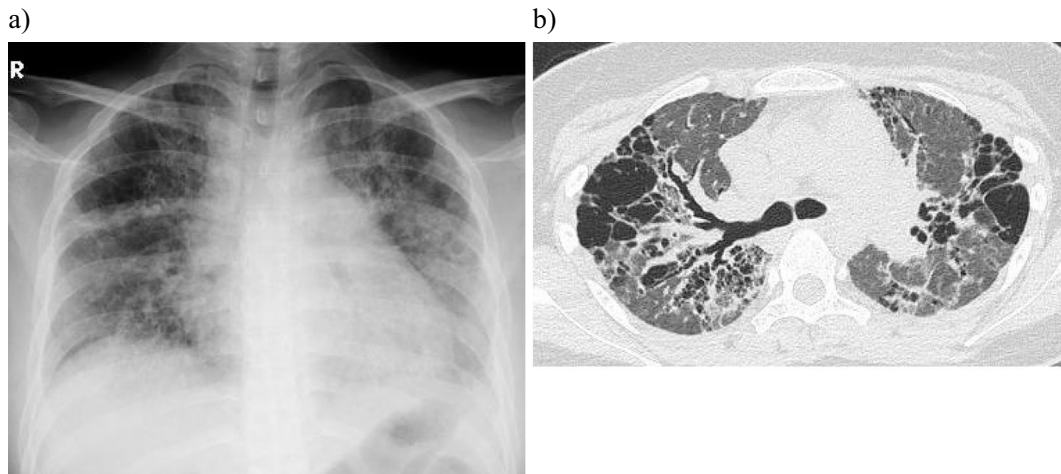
Radiological findings on admission. Chest radiography (a) and chest computed tomography (b) showed bilateral ground-glass opacities and cystic lesion.
